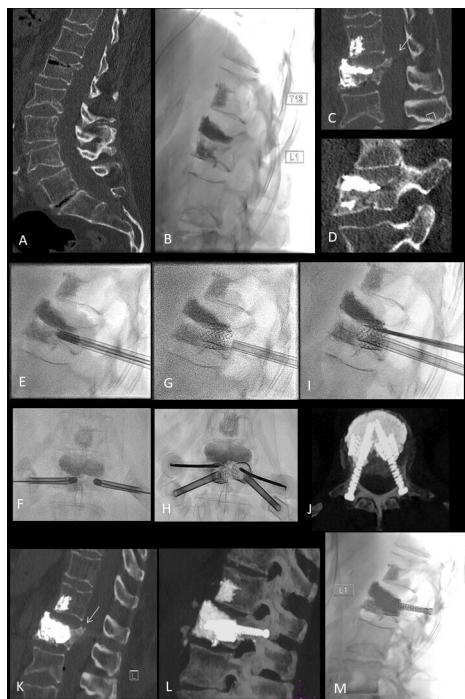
Patient 3. (A) CT scan showing fracture of L1 with air-filled cleft and chronic fracture of L2 and L4. (B) Lateral fluoroscopic view after vertebroplasty of L1 with good cement-filling both in the trabecular bone and in a large anterior cleft; prophylactic augmentation of T12. (C–D) CT scan 7 days later showing re-fracture of the middle column of L1 with posterior wall retropulsion (arrow on C). (E–I) Procedural fluoroscopic views of the modified stent-screw assisted internal fixation (SAIF) of L1: 4.5 mm bilateral trocars are inserted with extra-pedicular access (E–F), and small-size vertebral body stents are inserted and balloon-expanded in the posterior part of the vertebral body (G). Trans-pedicular access is then performed with 14G cannulas, exchanged with a k-wire to insert the fenestrated trans-pedicular screws into the stents' lumen. (K–L) Post-SAIF CT scan showing height restoration of the middle column collapse, bridging across the middle column and pedicles with the screw-stent-cement complex and partial correction of the posterior wall retropulsion (arrow in K). (M) Standing plain film at 4 years follow-up showing stable result.
